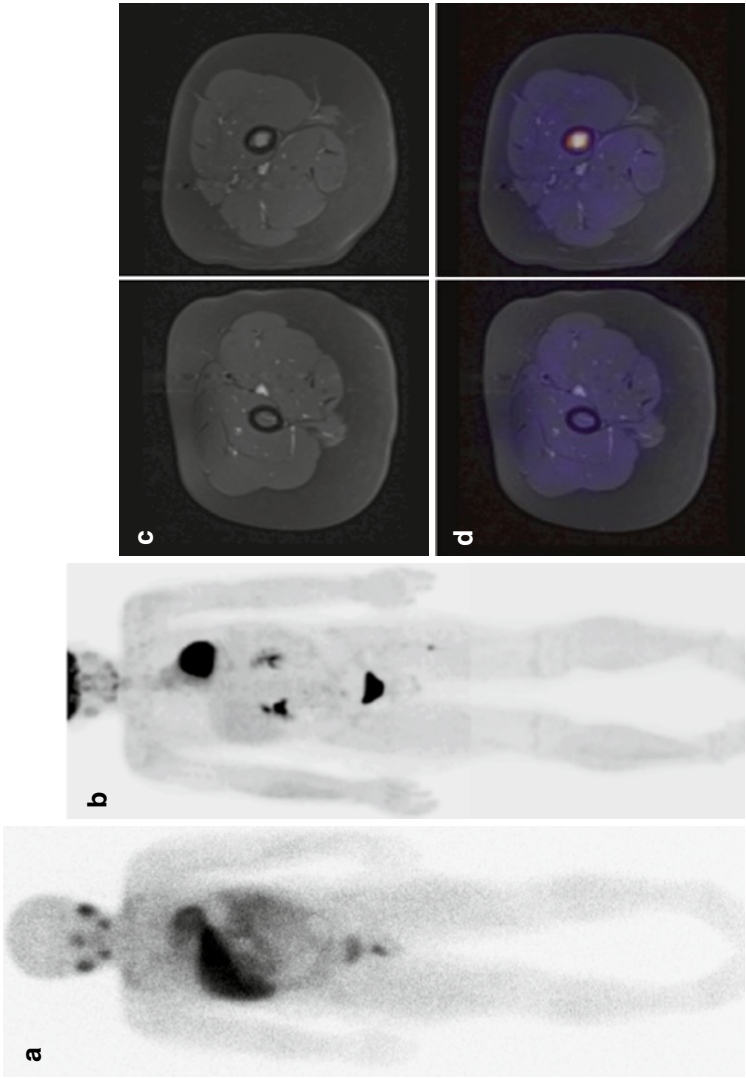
A paraganglioma demonstrates differential avidity for ^{18}F -FDG and ^{123}I -MIBG. (a) After resection of an abdominal paraganglioma, a surveillance ^{123}I -MIBG scan in anterior projection shows the expected normal distribution of ^{123}I -MIBG. (b) Four months later, a surveillance ^{18}F -FDG PET shows an abnormal focal uptake in the left thigh. (c) MRI of the lower extremities shows an enhancing intramedullary lesion in the left femur. (d) Co-registration of ^{18}F -FDG PET and MR images confirms that the enhancing marrow lesion is FDG-avid, consistent with paraganglioma. Genetic testing identified a germ line mutation in the SHDB gene, and the lesion was treated with radio-frequency ablation
